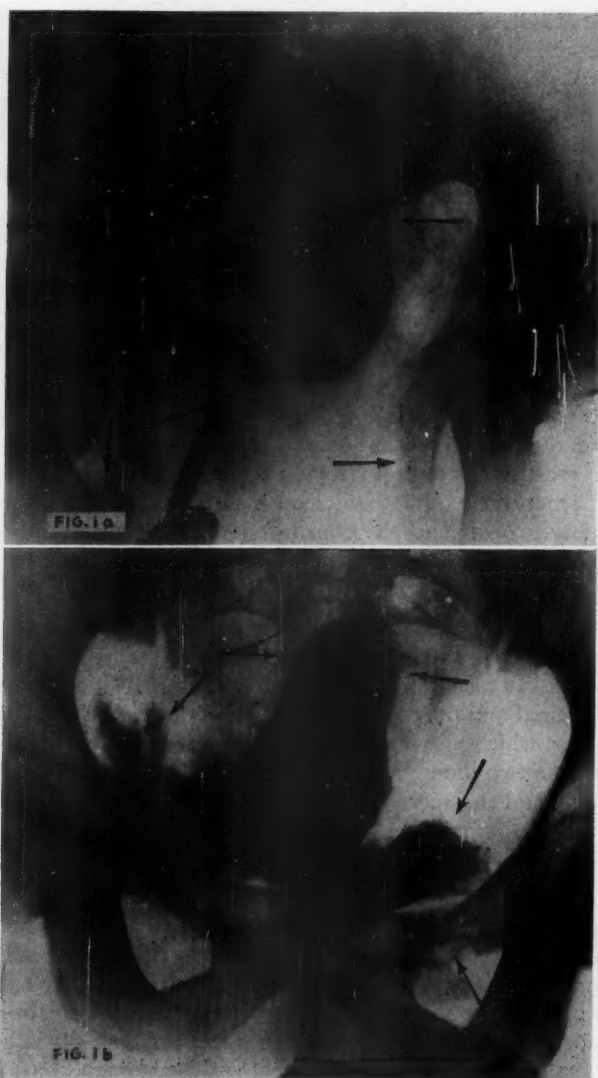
a and b. Showing roentgenograms with opaque material used as bladder injection to demonstrate injury to the bladder in pelvic fractures. (Courtesy Dr. Jarratt P. Robertson, Birmingham, Alabama). a. Shows pelvic fracture displaced markedly without any bladder rupture. b. Very slight fracture of pelvis with rupture of bladder being present. It is not always necessary to have marked pelvic fractures with displacements to produce severe bladder injury. The reverse is also true as shown in Fig. a. (Key and Conwell, *The Management of Fractures, Dislocations and Sprains*, Fifth Edition, 1951, C. V. Mosby & Co., St. Louis, Missouri.)
